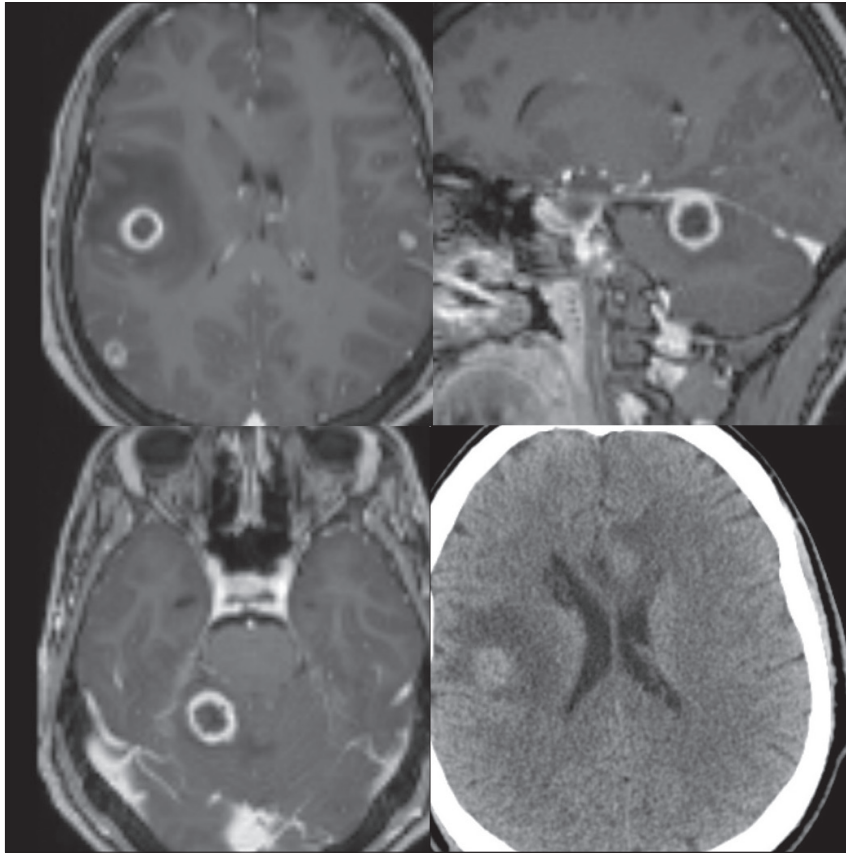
T1 contrast-enhanced MRI axial view shows multiple lesions in the right parietal lobe and tuberculoma lesions in the left parietal lobe, left frontal lobe, and right cerebellum tuberculoma lesion.
